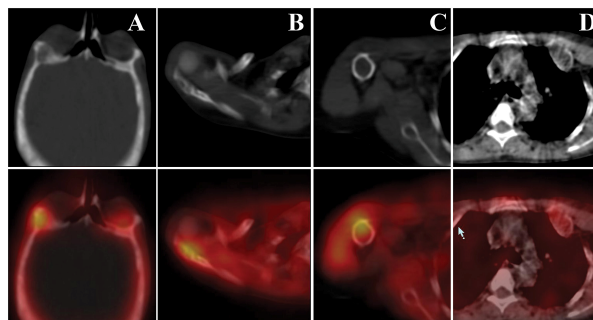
Hybrid SPECT/CT images: right orbital margin (A), lateral end of the right clavicle (B), right humeral shaft (C), multiple ribs (D).
